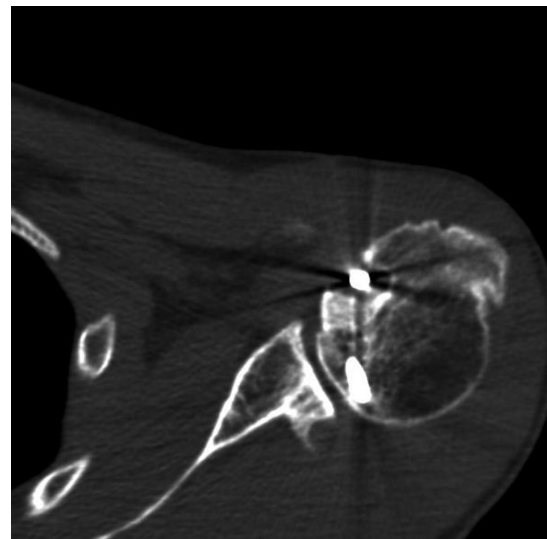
Postoperative radiograph of the right shoulder showing the reduced humeral head with restoration of the sphericity.
